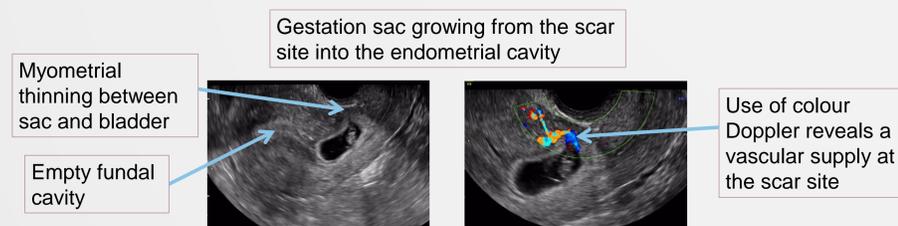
Sac to cervix view in a partial scar pregnancy Fig 5 – Sac to cervix view in a partial scar pregnancy with colour Doppler
